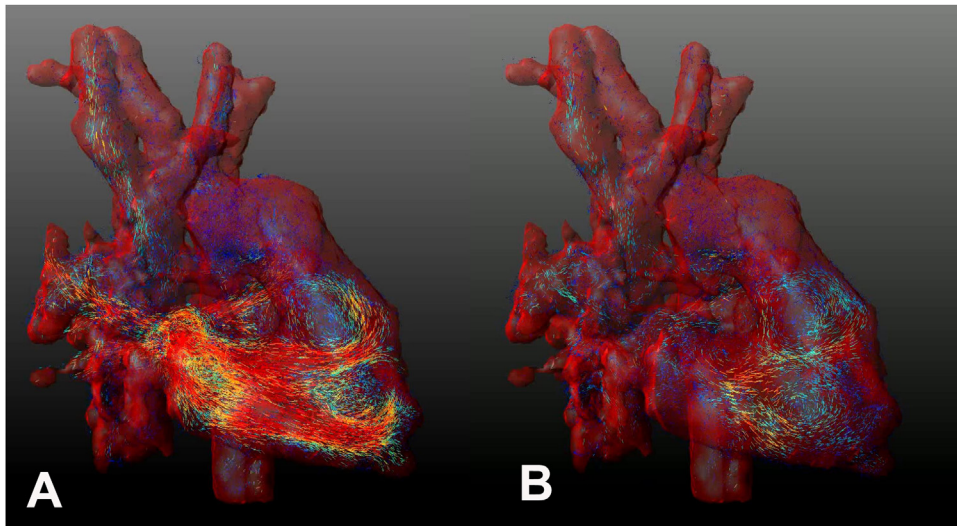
Flow in the single ventricle of a HLHS patient with Fontan circulation is acquired by 4D-flow MRI (right anterior oblique view). (A) Diastolic vortex ring developed from the trans-tricuspid jet; (B) vortex dissipation at end-systole.
